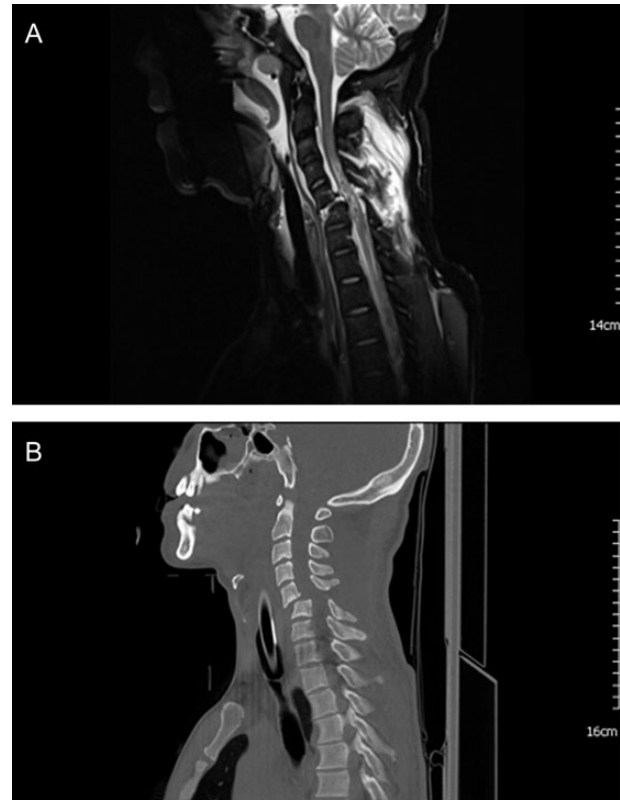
(A) MRI of cervical spine showing C5/6 bilateral facet displacement with disc disruption and extensive soft tissue disruption. Anterior displacement of C5 vertebrae on C6 vertebrae is demonstrated. There is cord swelling and contusion and a focal intramedullary haematoma at the level of C5/6, the cord oedema extends from C2/3 to C7. (B) CT of the same patient showing marked anterior subluxation of C5 on C6 and bilateral facet lock of C5/6. This CT is consistent with an unstable hyperflexion injury.
